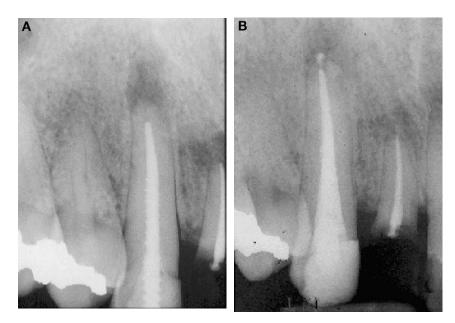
(A) Radiograph showing the presence of a long, threaded post associated with a failing root canal treatment. (B) Radiograph showing completion of root canal treatment after removal of the threaded post.
